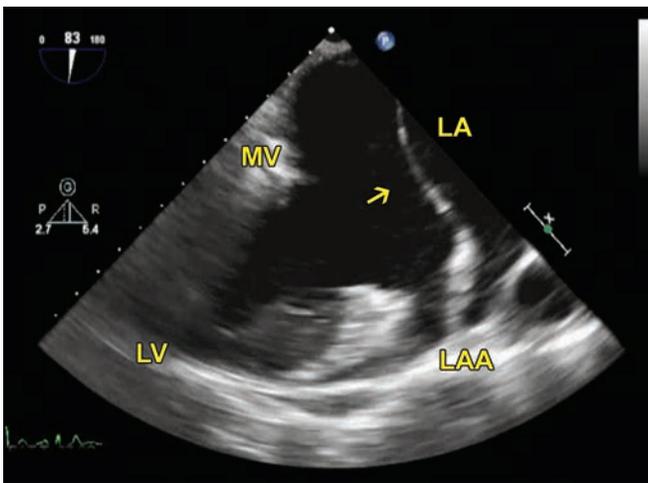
Transesophageal 2-chamber view. Arrow points to a linear echodensity in the left atrium.
